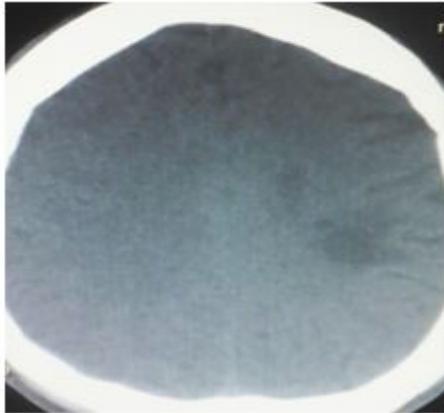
A hypodense lesion was seen on the parieto-occipital regions with an impression of parieto-occipital edema. Follow-up MRI was advised.
